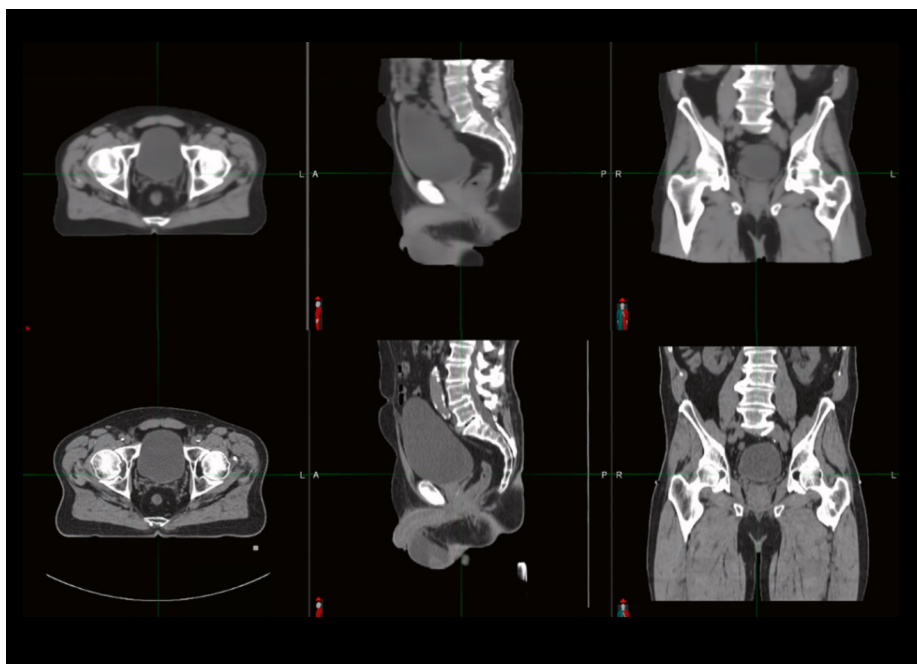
MR-based Synthetic CT (top) compared with conventional planning CT (bottom) of the same patient.
